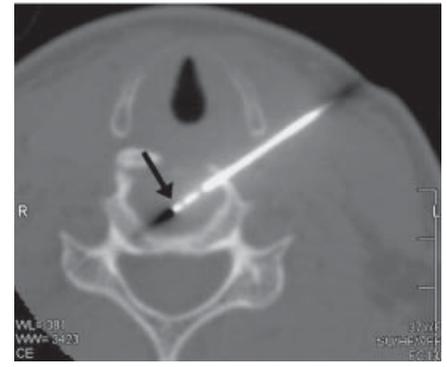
Axial CT fluoroscopic section showing the nucleoplasty electrode deployed, with the tip in the central portion of the disc space (black arrow).
